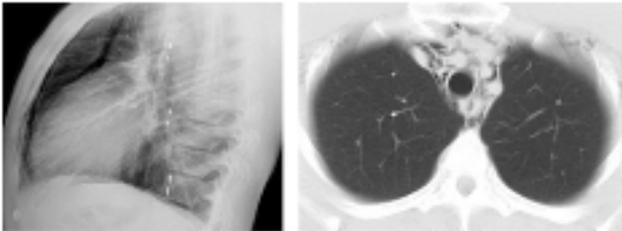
Pneumomediastinum on lateral chest X-Ray and thorax CT
